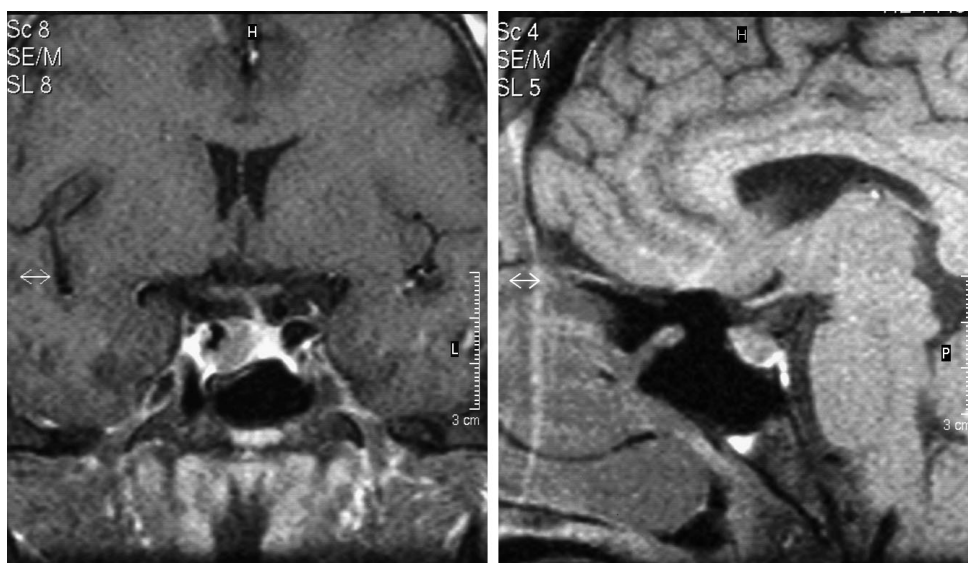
Cranial (left) and sagittal (right) enhanced MRI in the patient. The pituitary tumor (9 × 7 mm) occupied the sellar region adjacent to the right inner carotid artery.
